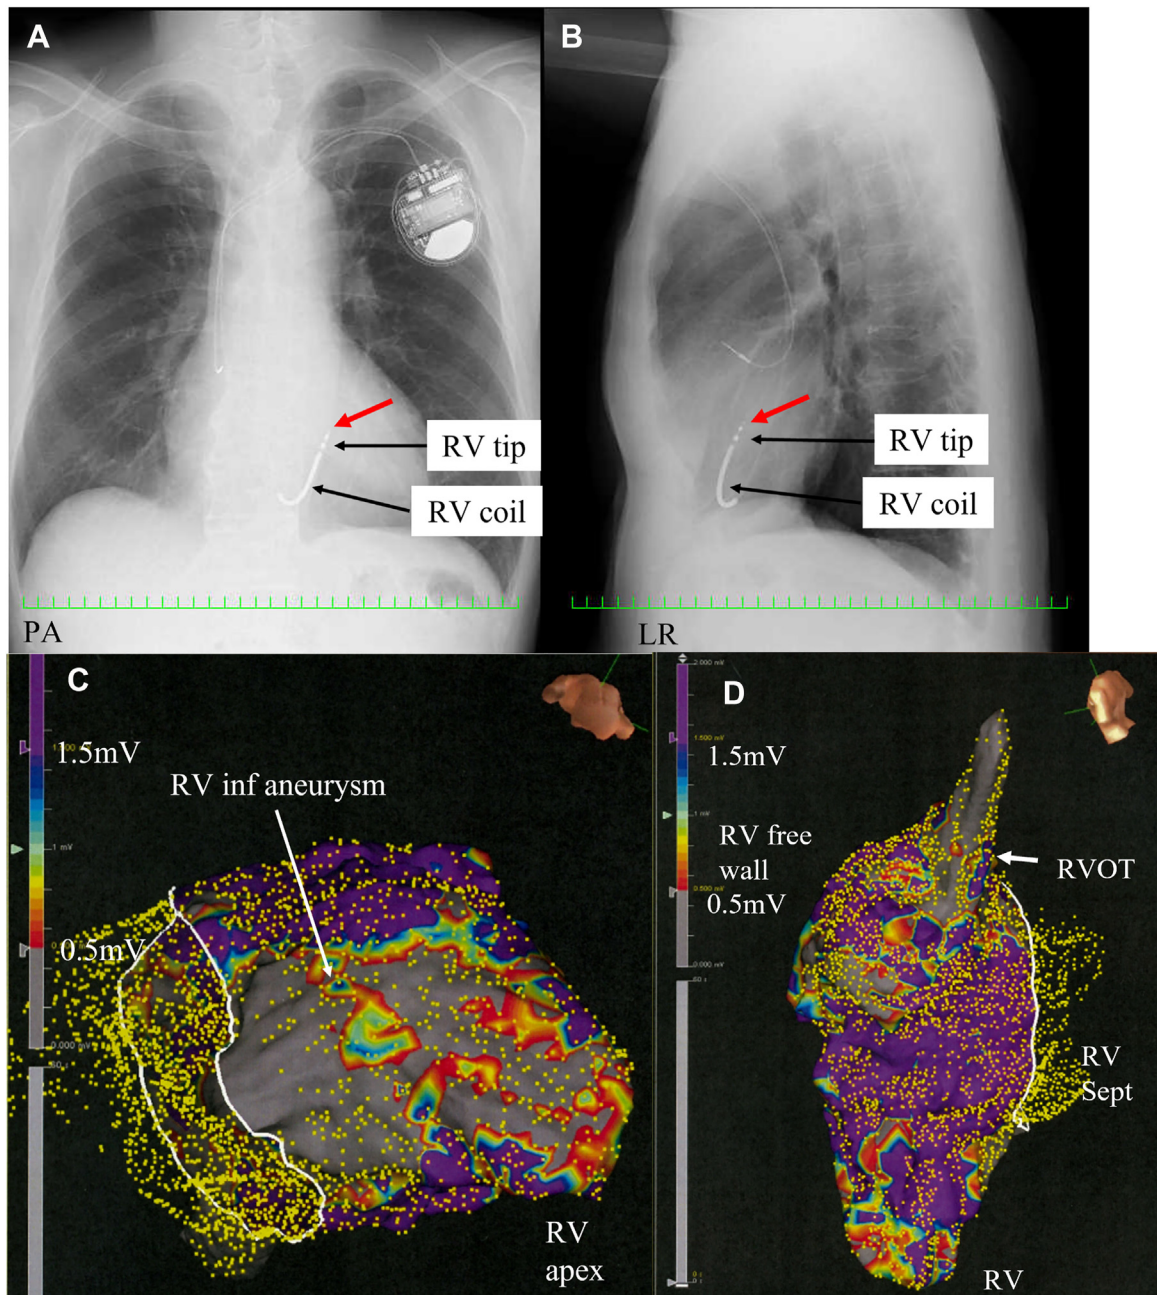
A: Chest radiograph (posterior-anterior [PA] view) after the implantable cardioverter-defibrillator (ICD) implantation. The right ventricle (RV) lead was positioned on the high RV septum (red arrow) because of the extensive low-voltage area at the apex and inferior wall. B: Chest radiograph (left-right [LR] view) after the ICD implantation. C: A voltage map of the RV (inferior view). An extensive low-voltage area (<1.5 mV: gray zone) was observed on the RV inferior wall and apex. D: A voltage map of the RV (superior view). An extensive low-voltage area (<1.5 mV: gray zone) was observed on the RV apex and RV outflow tract (RVOT). Inf = inferior; RV sept = right ventricle septum.
